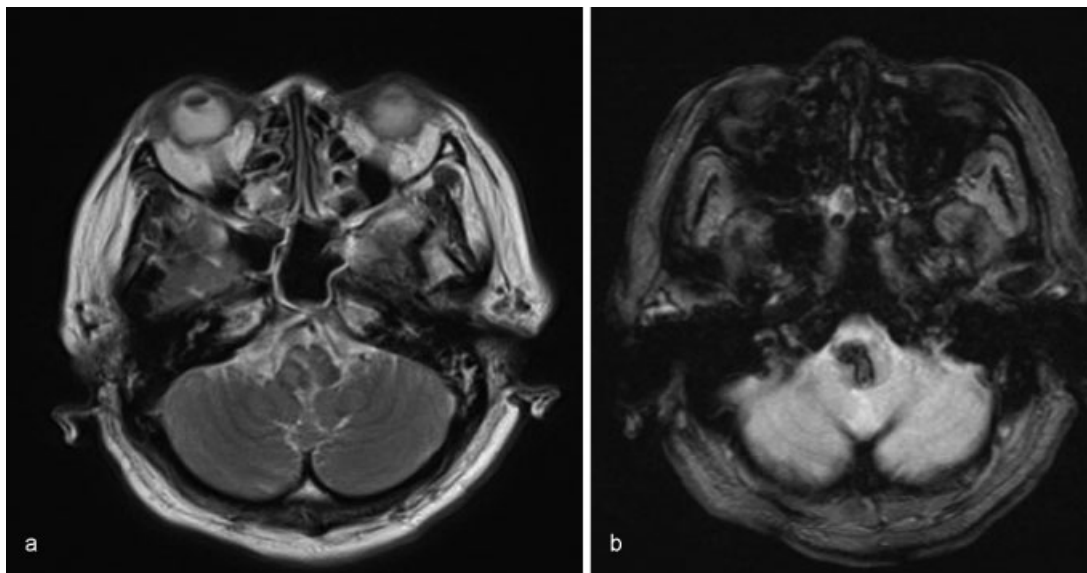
Magnetic resonance images revealed no apparent pathologic causes of hemorrhage. (a) T2 weighted. (b) T2* weighted.
